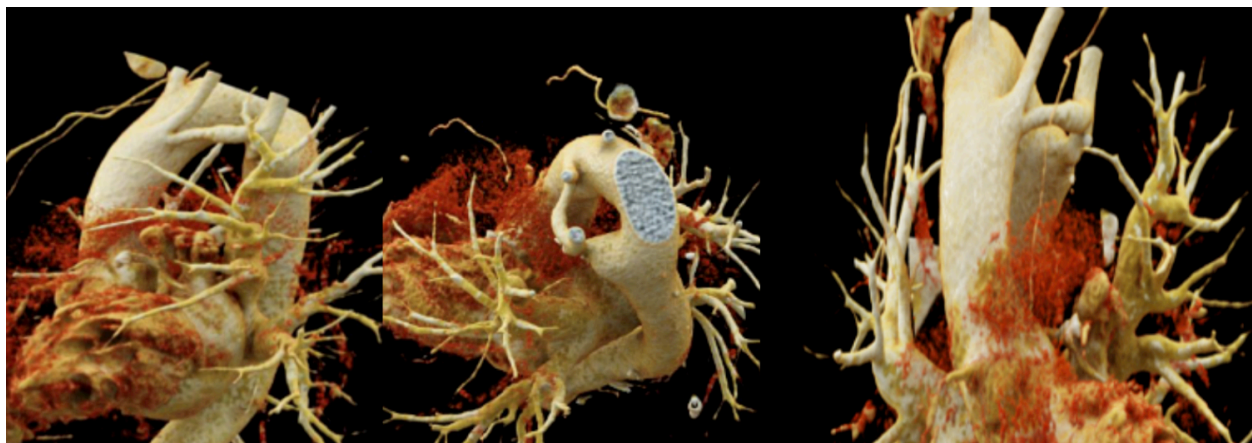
3-D reconstructions of the CT scan of the aorta showing the vessel that connects the ascending and descending aorta, as well as the various supraaortic branches.
